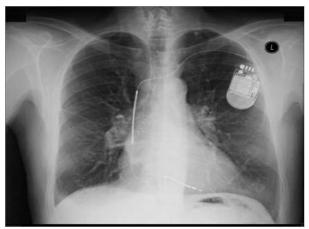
Chest X-ray showing the ICD box and lead; hilar congestion is also shown.
